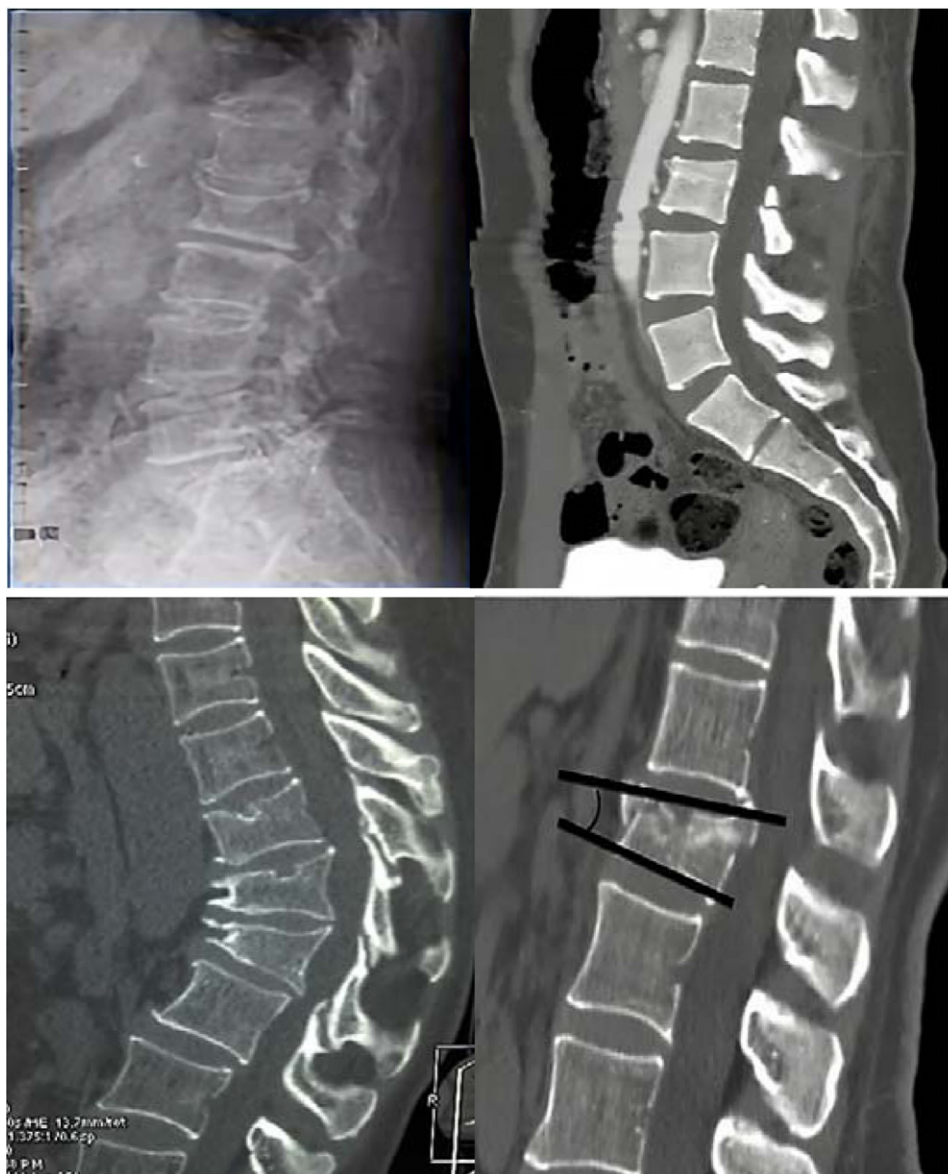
CT image of patients after FBP reconstruction algorithm.
